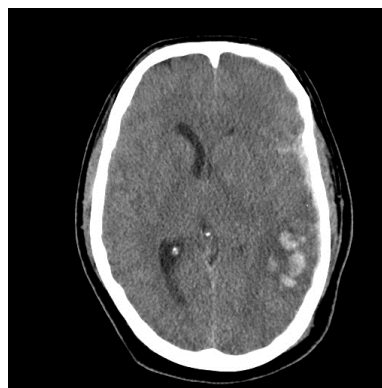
Axial CT section shows Diffuse cerebral edema noted. Subarachnoid hemorrhage noted in bilateral fronto-parietal lobes and left sylvian fissure and Hemorrhagic contusion seen in left temporo-parietal lobes
